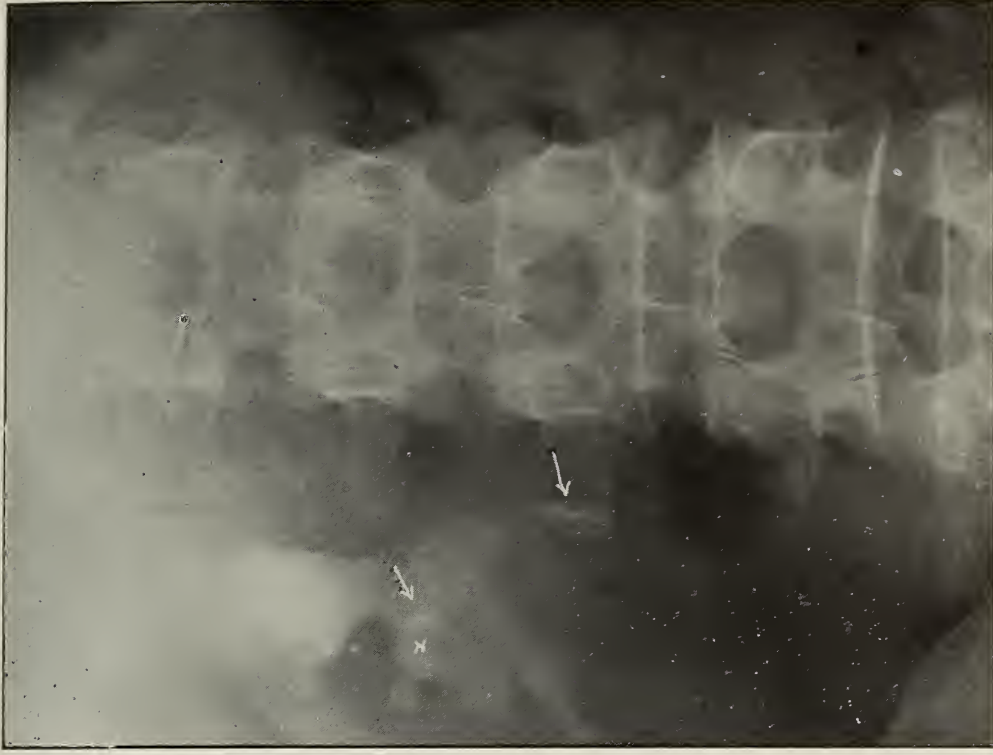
X-ray No. 13128, b. Colloidal silver locates suspicious shadows; shows larger one in middle calyx, other at ureteral-pelvic junction. Small distention of the upper calyx. At operation calculus removed from ureteral-pelvic junction.
